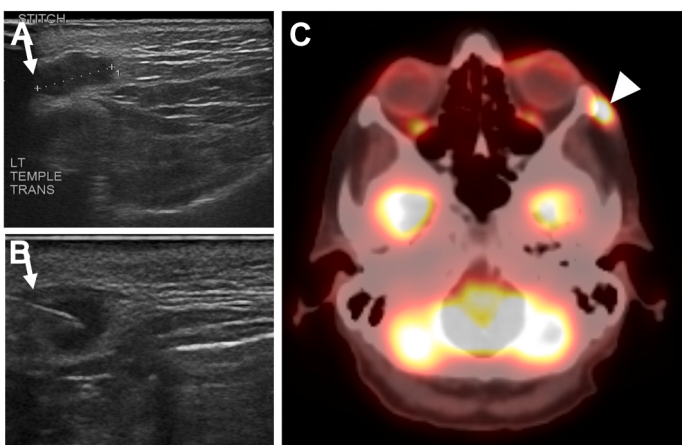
Patient with history of lateral canthus melanoma, with new subcutaneous nodule on dermatologic examination. Punch biopsy performed at dermatology clinic was negative for melanoma. (A) US image shows 1.1 cm hypoechoic subcutaneous nodule in left temple near surgical scar (arrow). (B) Simultaneously performed US guided fine needle aspiration of the nodule was positive for melanoma (arrow). (C) Subsequent ^{18}F -FDG PET-CT demonstrates FDG avidity at the site of biopsy proven melanoma recurrence in left temple (arrowhead).
